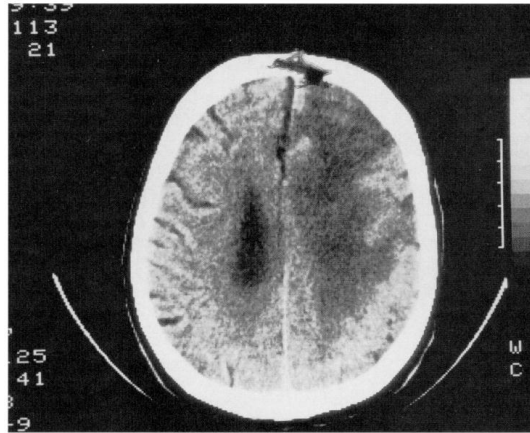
Follow-up computed tomography 3 days later showing hypodense lesion of the right hemisphere.
